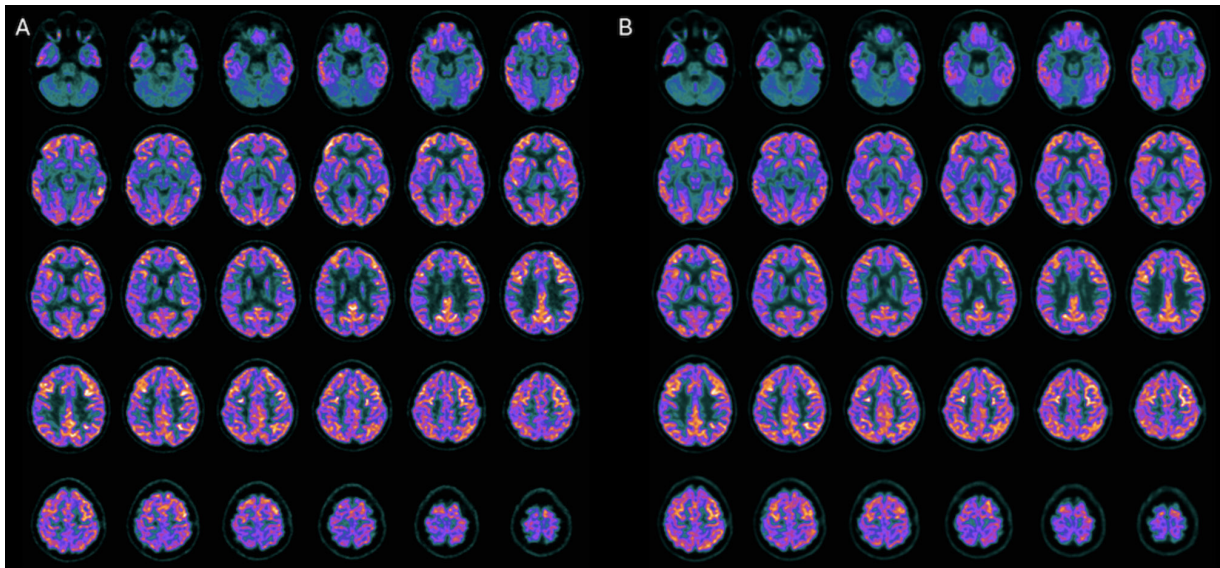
18F-FDG PET brain axial slices performed before (A) and after (B) NGF treatment. A, Mild reduction of 18F-FDG uptake in bilateral parietal cortex, subcortical regions, and a slightly more severe reduction in cerebellum. B, After the NGF administration, an increase of the radiotracer uptake in the bilateral parietal cortex (right: +7%; left: +6%), right and left caudate nucleus (right: +3%; left: +5%), and cerebellum (+6%) was observed.
